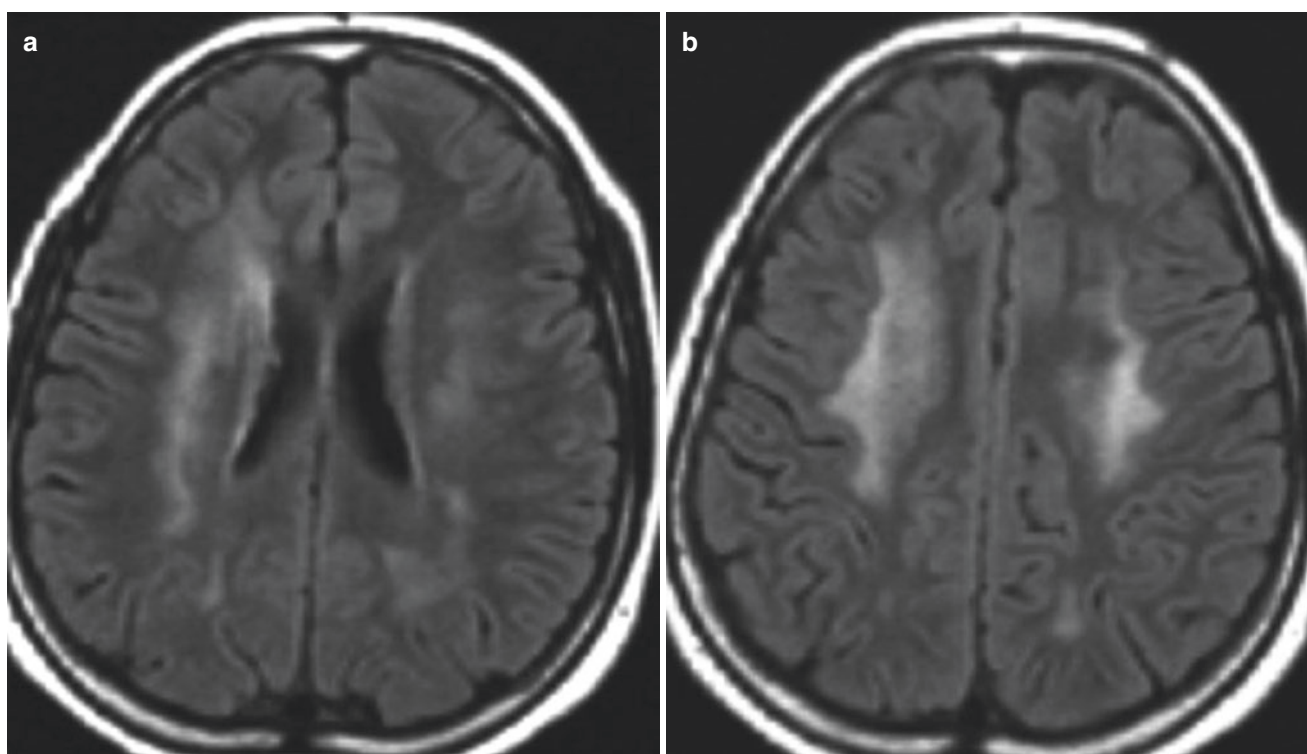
(a, b) MR FLAIR sequences show diffuse bilateral hyperintensity of the periventricular white matter
